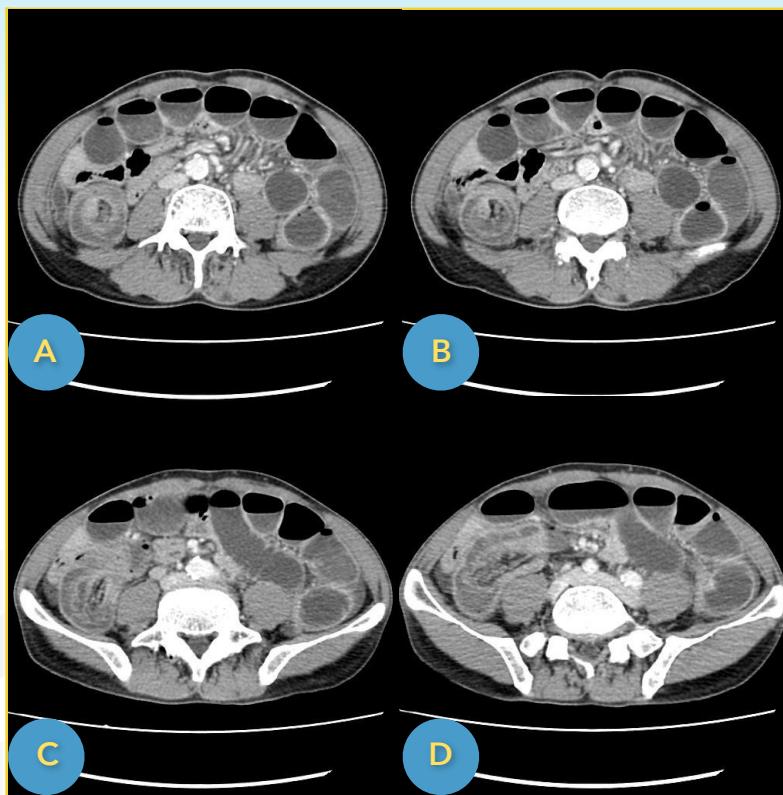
Abdominal computed tomography in adult intussusceptions.
